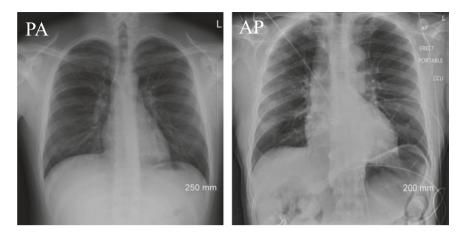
PA and AP chest radiograph side by side for comparison. Note how the cardiac and mediastinal silhouettes are magnified on the AP view (right), and the scapulae are less retracted
